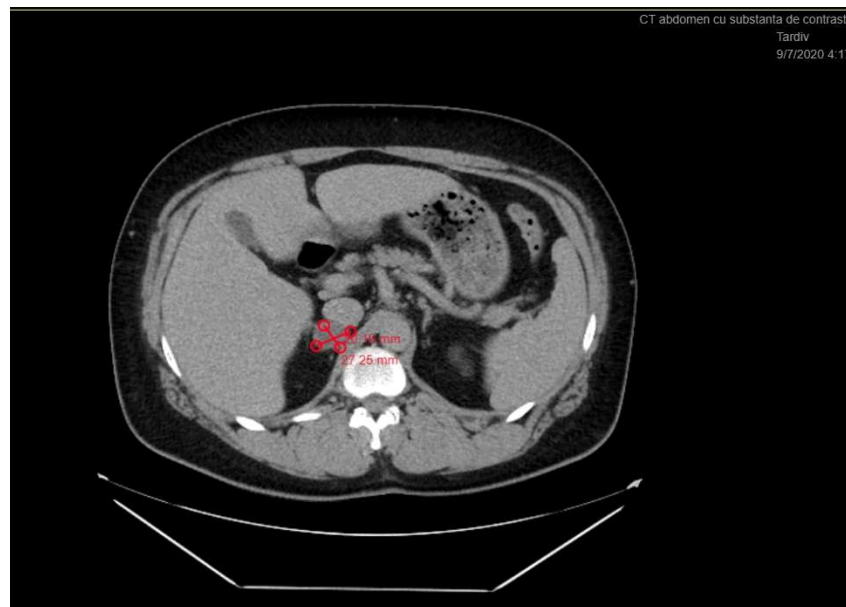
Contrast-enhanced computed tomography scan of the adrenal glands showed a hypodense oval lesion, 27/20 mm, affecting the body and the medial limb of the right adrenal gland. The left adrenal gland was normal.
